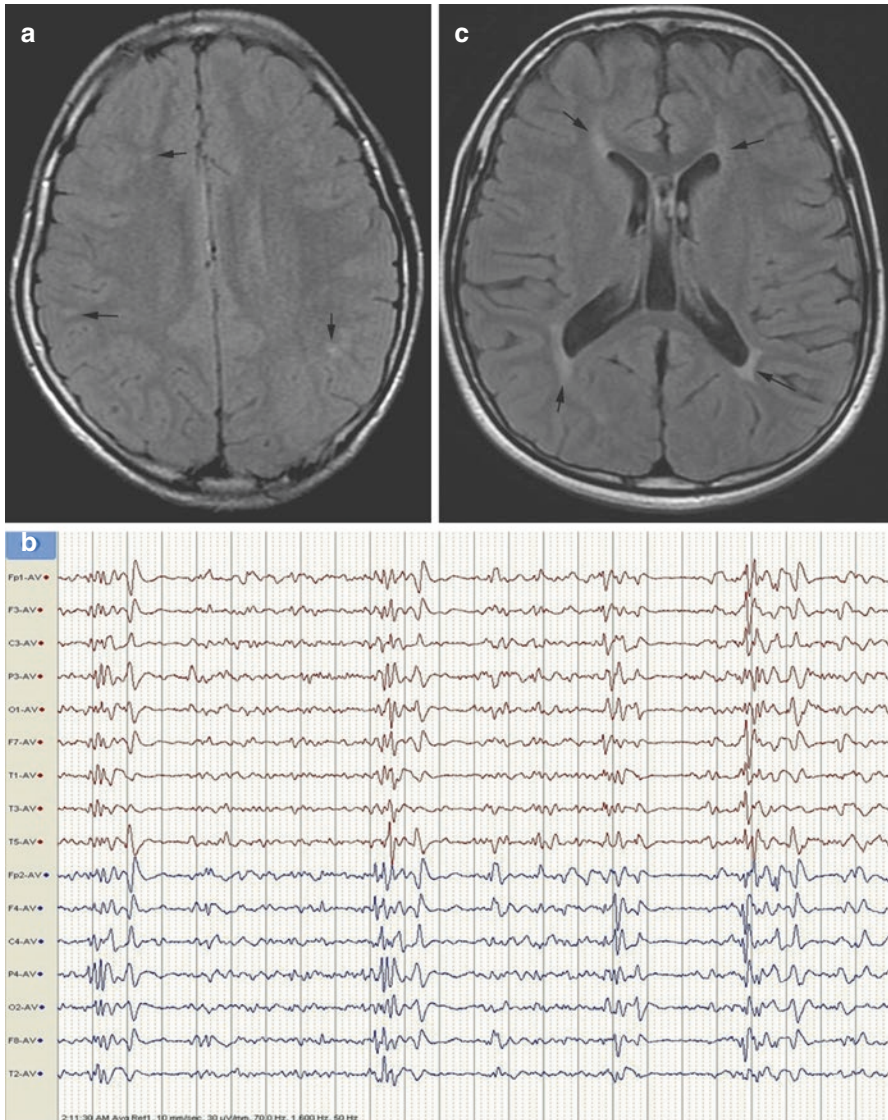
(a) A 12-year-old male with subacute sclerosing panencephalitis (SSPE) in clinical stage III. Axial fluid-attenuated inversion recovery MRI image. Note subtle white matter lesions in the subcortical regions (*arrows*). There is no cerebral atrophy. MRI changes do not correlate well with the clinical stage of disease. (b) Electroencephalography of the same patient as (a) showing characteristic periodic complexes, appearing in 6 s and lasting for 2 s on a slow background. Focal frontal slow waves are also recorded. (c) Axial fluid-attenuated inversion recovery MRI in a different 13-year-old male patient with stage II SSPE. White matter lesions (*arrows*) are seen in the parieto-occipital periventricular and frontal periventricular white matter. There is cerebral atrophy. The patient had a worse looking MRI than the patient in (a) despite being clinically better
